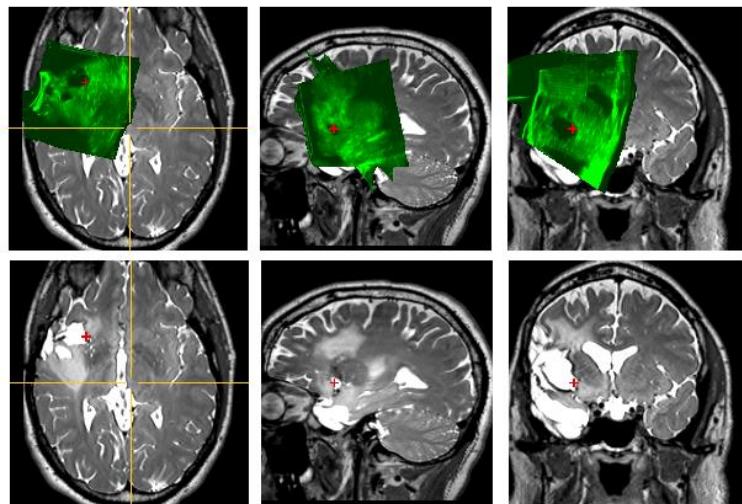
Top row: Updated neuronavigation visualization scene with the latest acquired 3D US volume rendered on the top of MR. Bottom row: Pre-operative MR image (The cavity at the left of axial view is from a previous resection)
